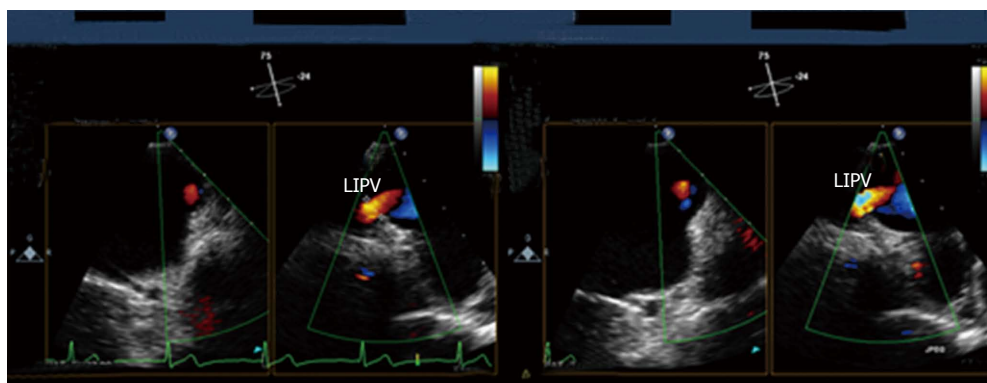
Three-dimensional transesophageal echocardiography performed 3 years after catheter ablation of atrial fibrillation. Slightly increased flow velocity in the left inferior pulmonary vein (LIPV) ostium indicating a minor pulmonary vein stenosis [pulmonary vein diameter at 3-year follow-up: 2.1 mm (compared to 2.6 mm at baseline)].
